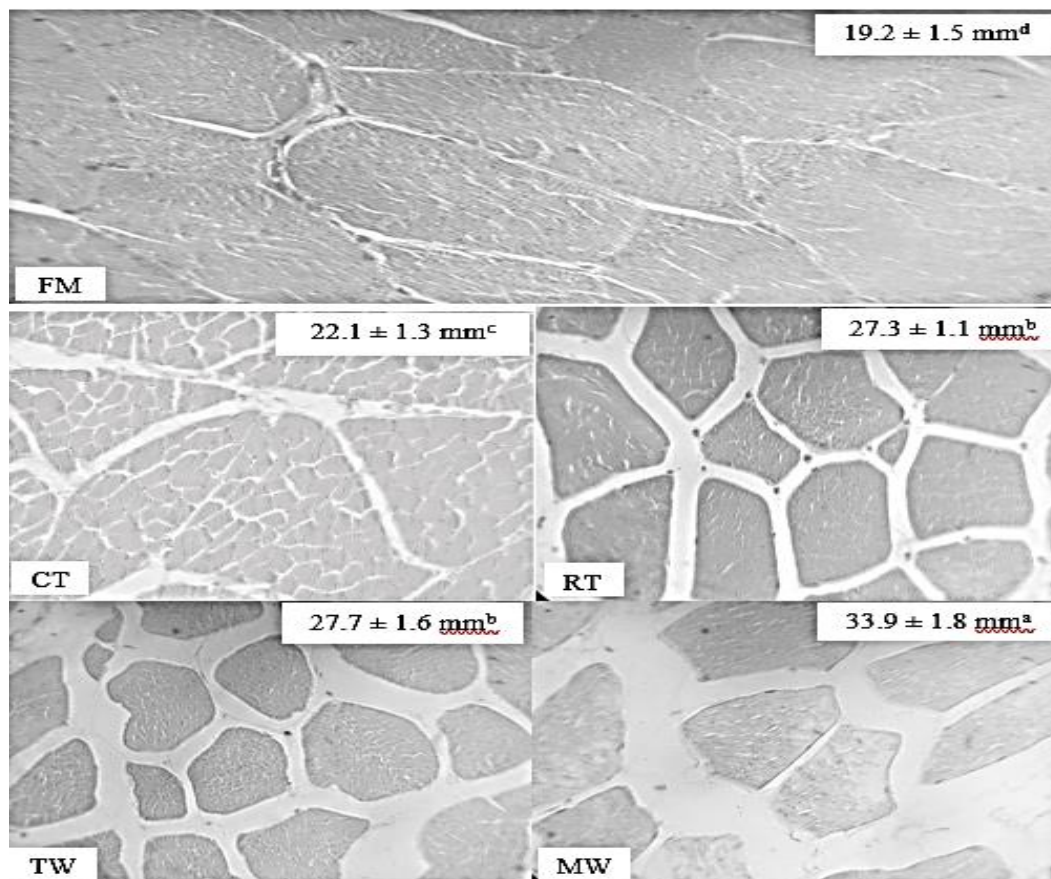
Change in microstructure of longissimus lumborum muscle subjected to chill temperature (CT), room temperature (RT), tap water (TW) and microwave (MW) thawing in comparison to fresh meat (FM).
